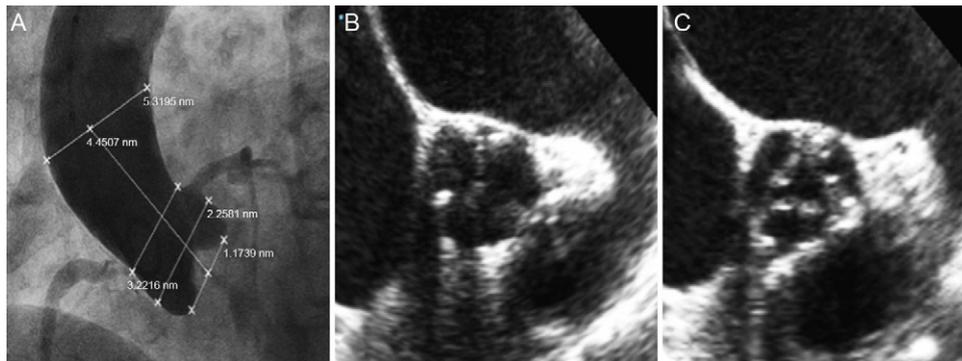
Images prior to percutaneous aortic valve implantation. A: aortogram. B and C: short-axis transesophageal echocardiography at the level of the aortic valve plane that allows visualization of the aortic valve, which is circular with moderate calcification and symmetrical distribution in systole and diastole.
